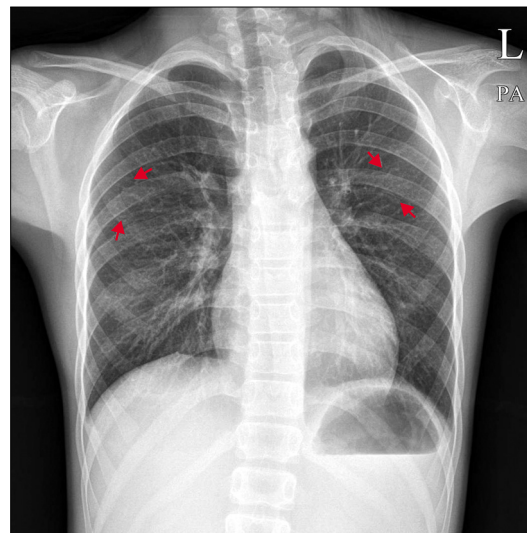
Chest x-ray view showing bifid ribs in the posterior aspect of both 3rd rib.
